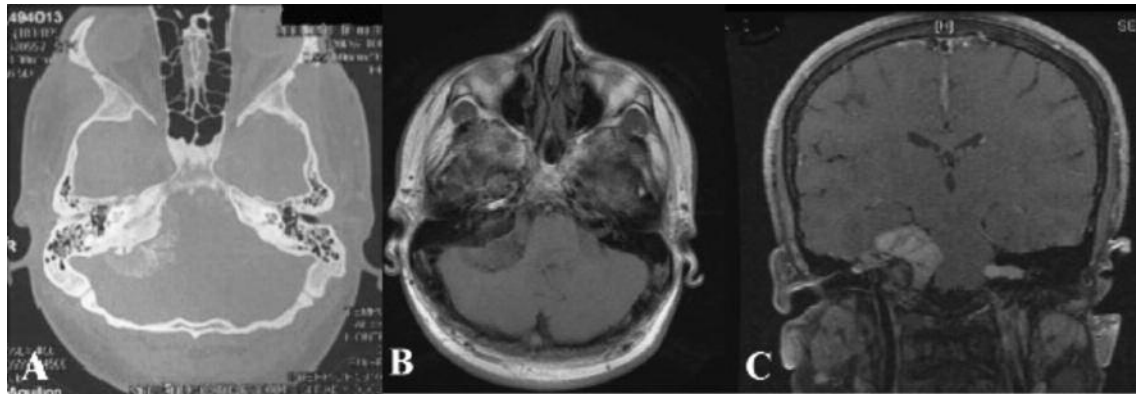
Right meningioma and left schwannoma in NF 2 case. A: Axial CT shows calcification in the lesion and hyperostosis in right temporal bone; B: Axial T1 WI shows a heterogeneous iso-hypointense lesion on the right side and isointense lesion on the left side; C: Coronal T1 WI shows contrast enhancement on both space occupying lesions.
